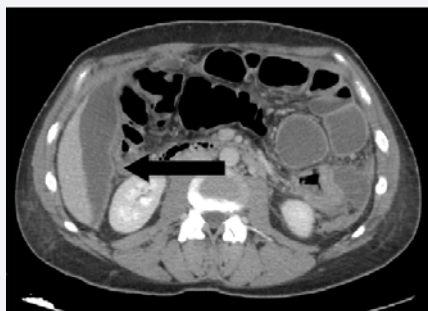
CT scan collections under the liver.
